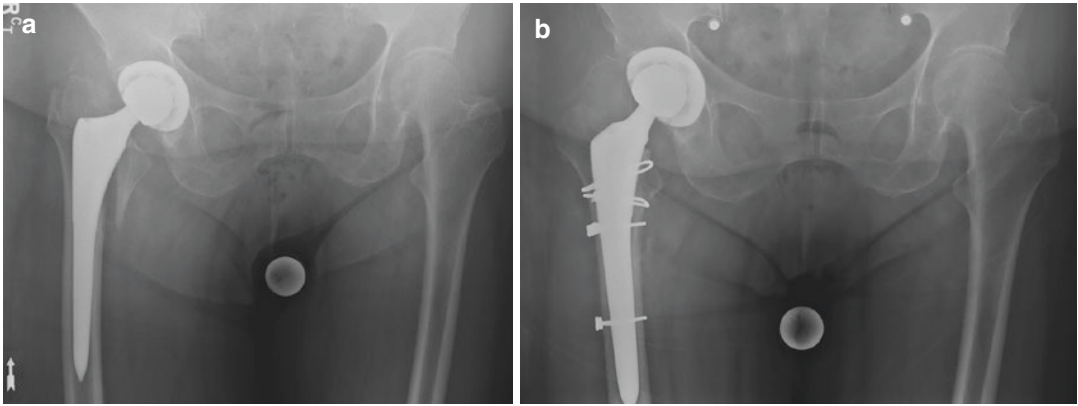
(a) Anteroposterior radiograph of a right-sided periprosthetic fracture with peritrochanteric comminution resulting in stem subsidence. (b) Postoperative
